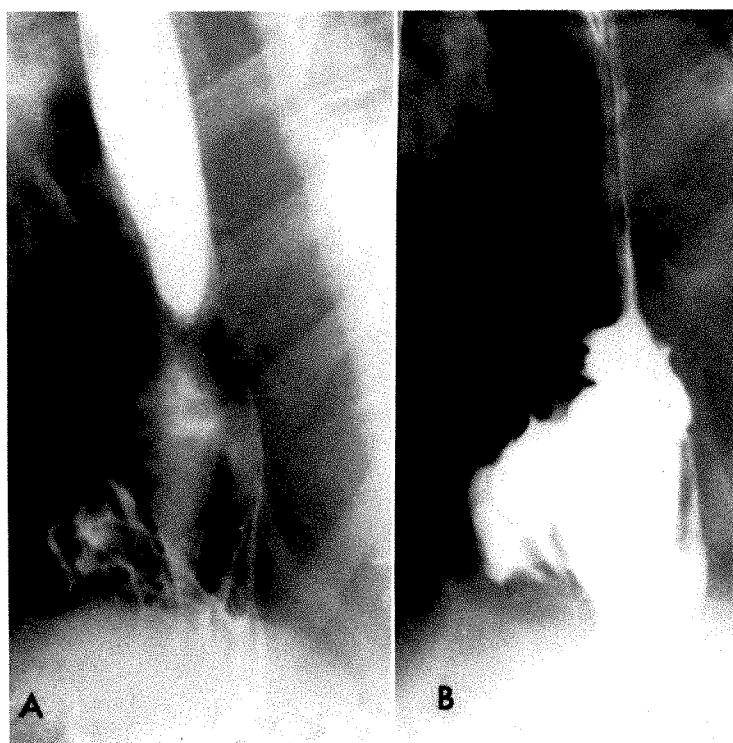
(A) Roentgenogram shows barium bolus approaching the proximal end of the hernia. (B) Roentgenogram made 2 or 3 seconds later shows the contracted esophagus which has propelled the bolus into a hernia, thus proving that the esophagogastric junction is *above* the diaphragm; *i.e.*, the hernia is of the sliding type.
